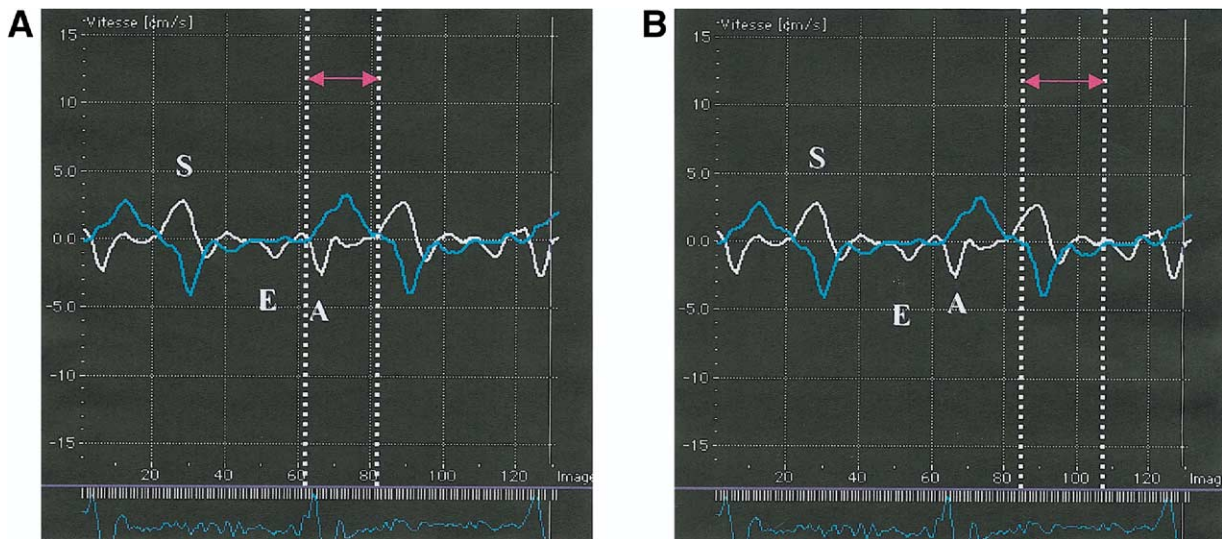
Methods of measurements of systolic and diastolic delays. (A) Measurement of systolic intraventricular delay. Tissue Doppler imaging recordings of the velocity curves of the septal wall (blue curve) and of the lateral wall (white curve) in a patient with severe systolic intraventricular asynchrony. The onset of each systolic velocity curve is used for measurement of systolic electromechanical delays of each ventricular wall (dotted lines). A systolic intraventricular delay of 95 ms between these two walls is calculated (pink arrow). (B) Similar measurements are performed for measurement of diastolic intraventricular delay in the same patient. The onset of each diastolic velocity curve is used for measurement of diastolic electromechanical delays of each ventricular wall (dotted lines). A diastolic intraventricular delay of 115 ms between these two walls is calculated (pink arrow).
